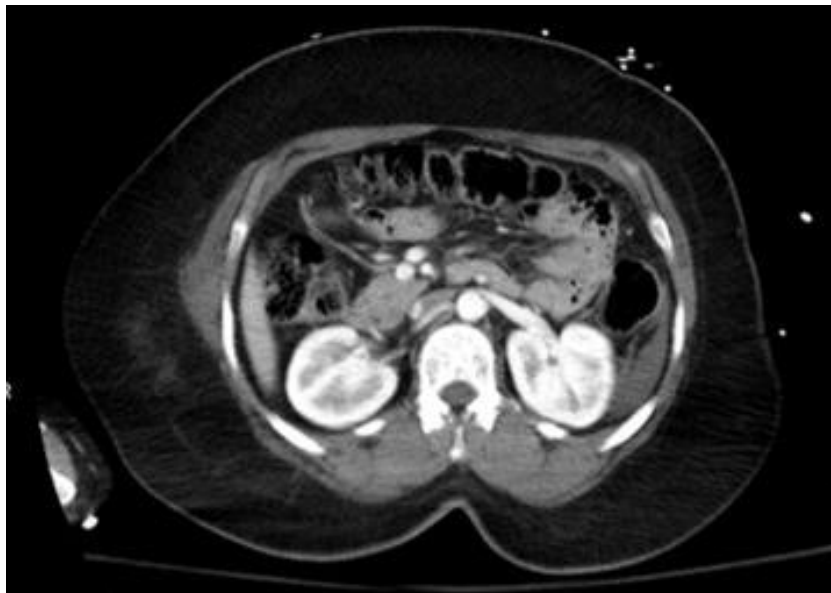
Subcutaneous fat appearance on the CT scan in absence of traumatic fat stranding.
